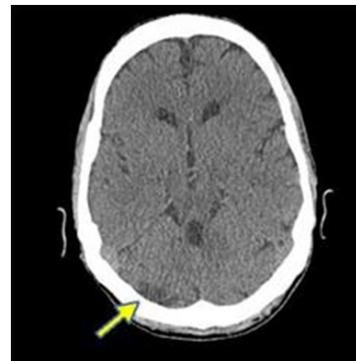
CT brain showing low attenuation in right cerebellar (Arrow).
